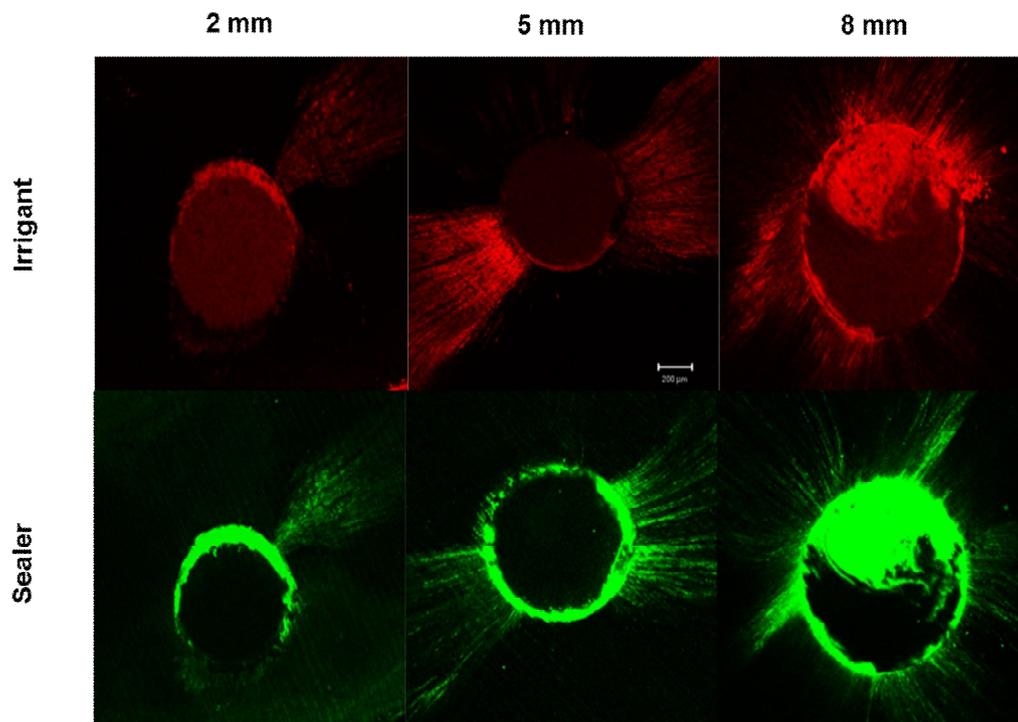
Representative CLSM images of both irrigant and sealer from ultrasonic group (original magnification, $\times 50$) at 2 mm, 5 mm, and 8 mm levels. The upper images (red) represent Rhodamine B-mixed NaOCl while the lower images (green) represent FITC-mixed root canal sealer.
